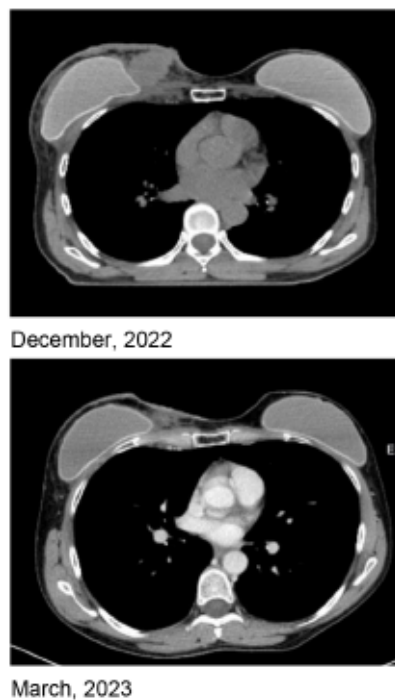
CT-scan appearance of the lesion before and after EBRT.
